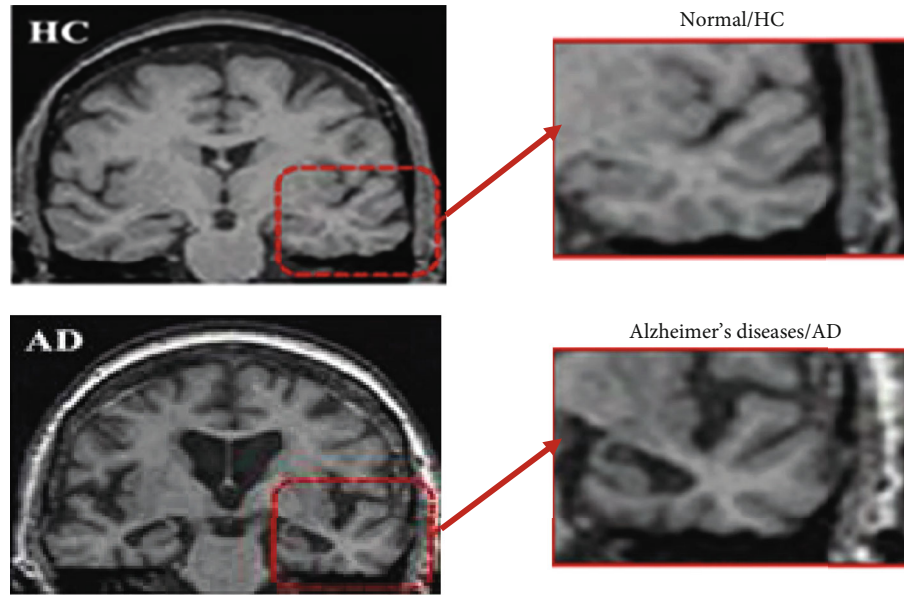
Image analysis of MRI related to Alzheimer's disease by using ML [4].
